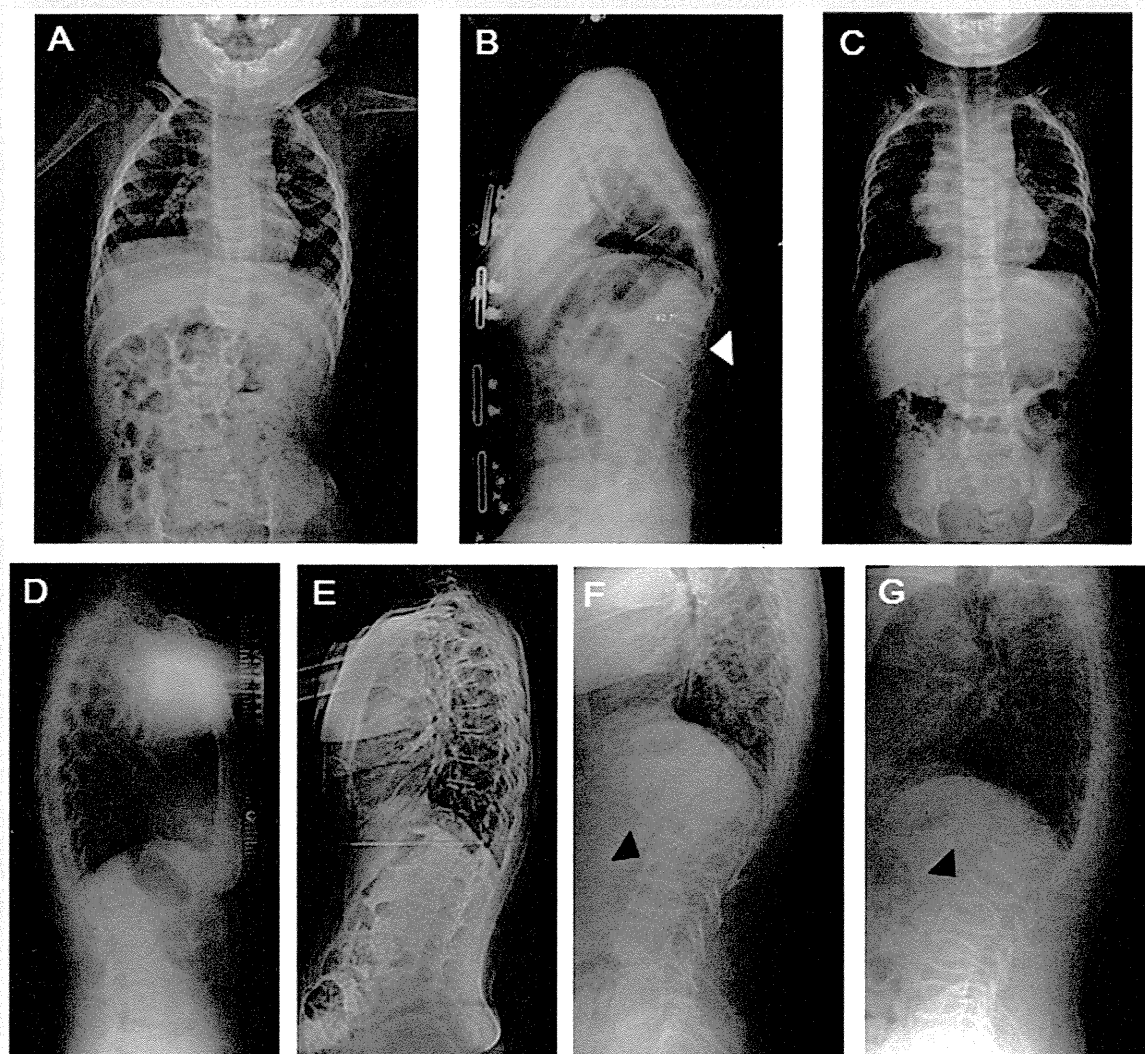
Radiographs of the spine. A: Patient 1 at 2 years and 4 months of age. B: Patient 2 at 14 years of age. Osteoporosis with vertebral compression was indicated by white arrow heads. C: Patient 3 at 2 years of age. D: Patient 4 at 31 years of age. E: Patient 5 at 41 years of age. Patient 6 at 20 years of age [F] and his mother, Patient 7 at 46 years of age [G] showed biconcave shape of compression fractures [black arrow heads].
